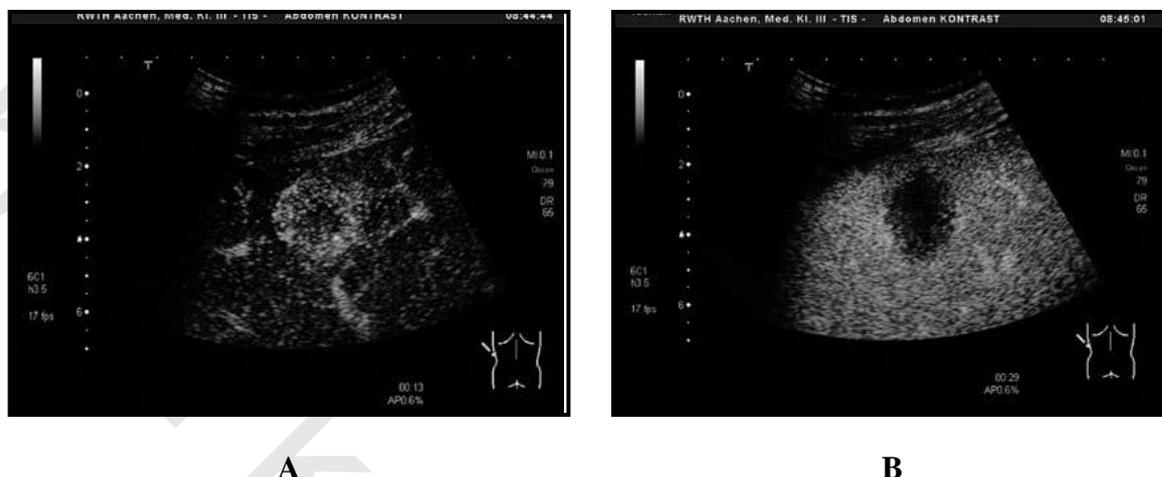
Contrast enhanced ultrasound. A) A representative liver metastasis after 13 s of contrast agent injection with early contrast enhancement; B) A representative liver metastasis after 29 s of contrast agent injection with loss of contrast enhancement⁽²⁶⁾.
